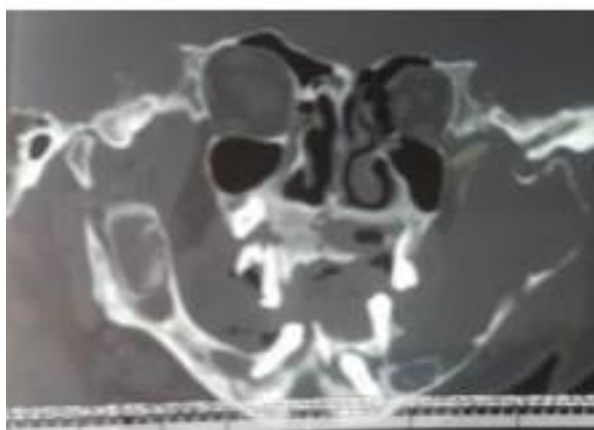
Massive facial CT (coronal section).
